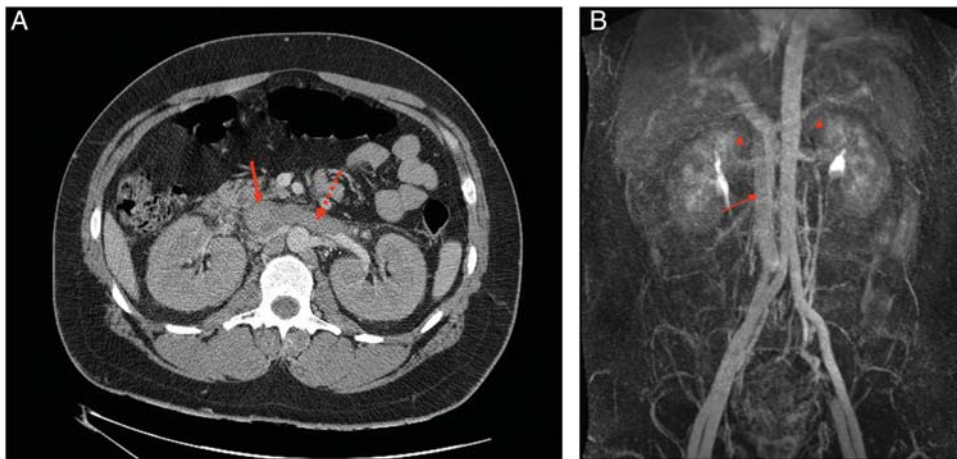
Radiological imaging of renal veins. (A) Initial contrast enhanced CT scan demonstrating acute thrombus and venous distension within the IVC (solid arrow) and left renal vein (broken arrow). (B) Magnetic resonance venography 3 months later demonstrating patency of the IVC (arrow) and bilateral renal veins (arrow heads).
